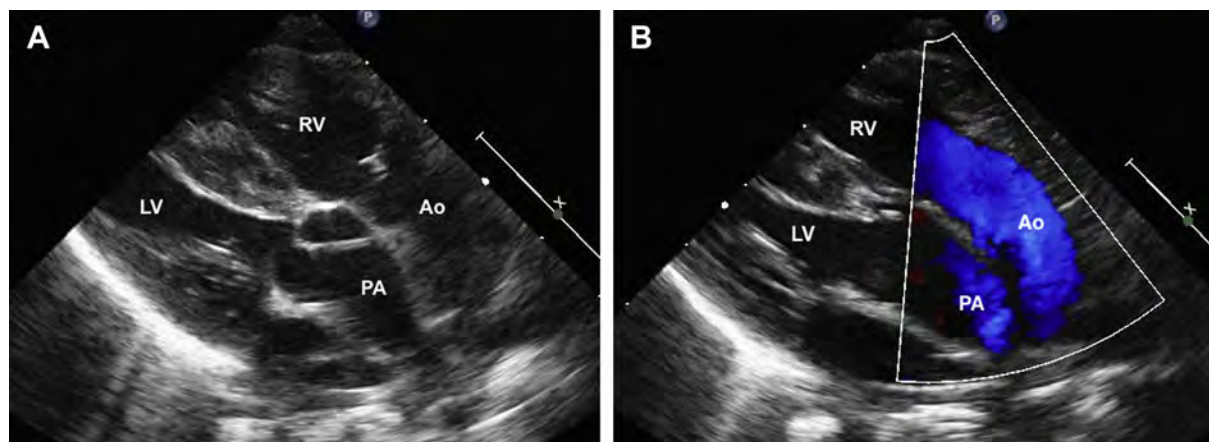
(A) Parasternal long-axis view of a patient with TGA and intact ventricular septum demonstrates the parallel relationship of the great arteries. (B) The same view with color flow demonstrates unobstructed flow to both great arteries. Ao, Aorta; LV, left ventricle; PA, pulmonary artery; RV, right ventricle.
